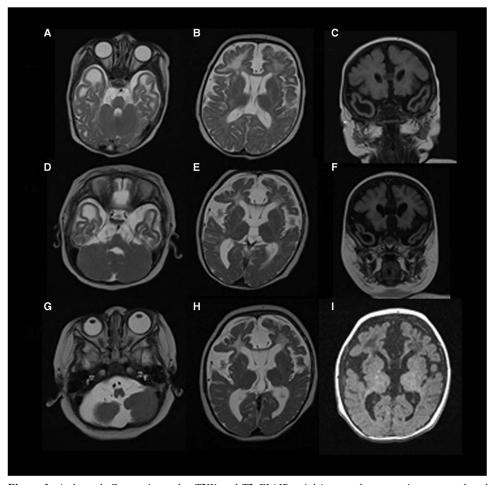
A through C, age 4 months, T2W and T2 FLAIR axial images demonstrating temporal and frontal cysts; D through F, age 11 months, T2W and T2 FLAIR axial images demonstrating temporal and frontal cysts and abnormal myelination status; G, age 18 months, T1W axial image demonstrating left glaucoma; H, age 18 months, T2W axial image demonstrating ongoing cerebral atrophy; I, age 18 months, T1W axial image demonstrating basal ganglia calcifications.
